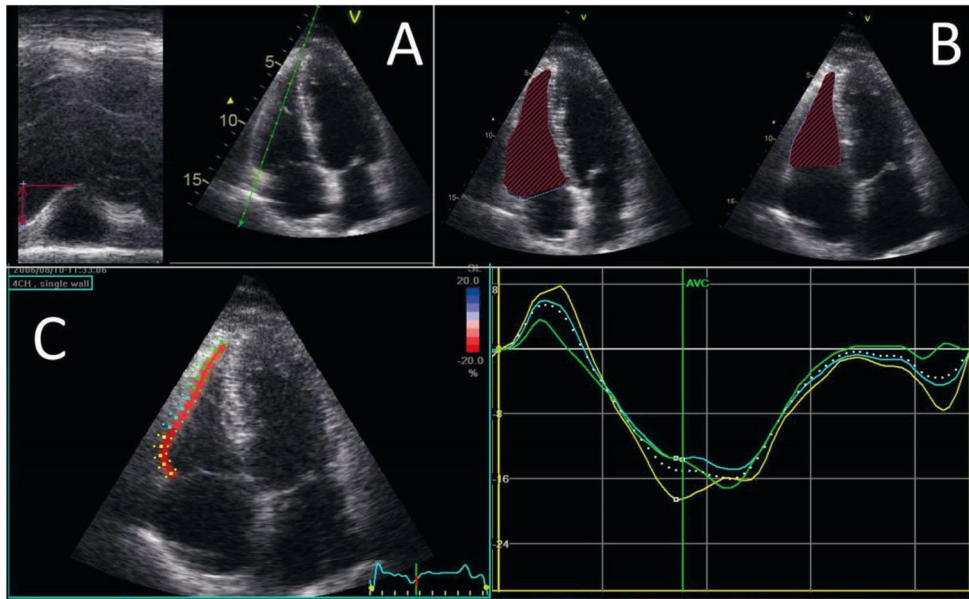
Right ventricular systolic function assessment in a ST-segment elevation myocardial infarction patient with chronic obstructive pulmonary disease. Example of a patient with normal right ventricular (RV) systolic function when assessed with conventional parameters such as tricuspid annular plane systolic excursion (TAPSE; panel A) or fractional area change (FAC; panel B), but impaired RV systolic function when assessed with advanced speckle tracking echocardiography (free wall strain longitudinal [FWSL]; panel C).
